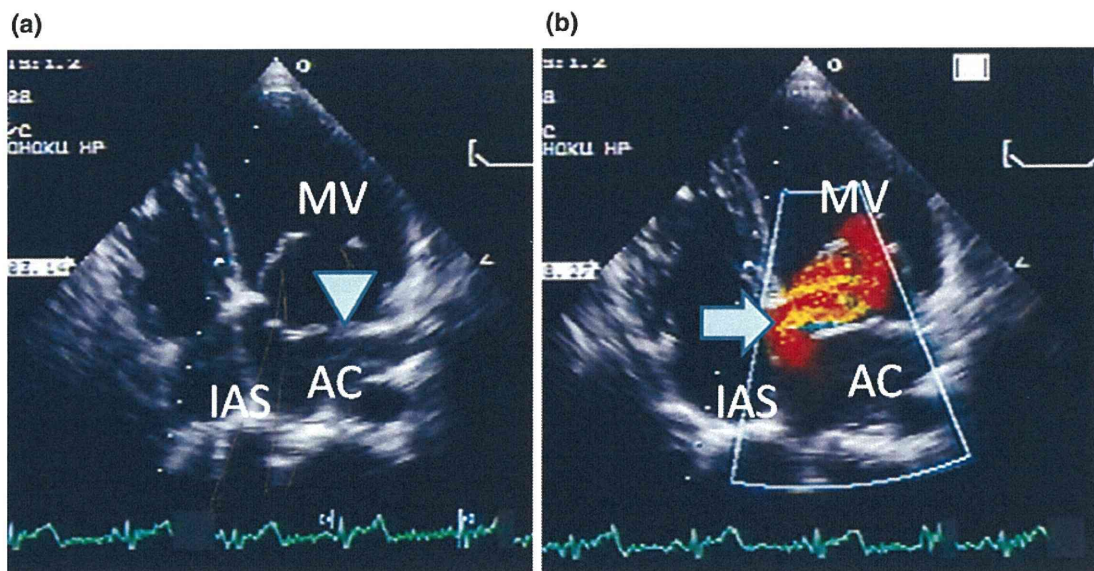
a The anomalous membrane (inverted triangle) is visible in 4 chamber view. b Color Doppler echocardiogram. Blood stream (arrow) from the accessory chamber (AC) into the left atrium toward the mitral valve (MV) along the interatrial septum (IAS)
